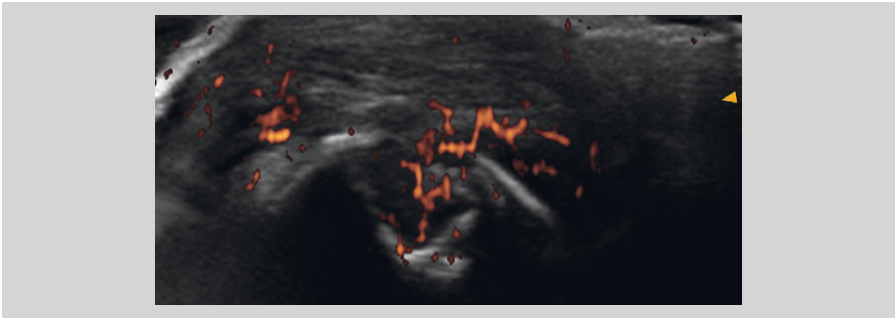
Ultrasound-detected erosion of a metacarpal head in a dorsal longitudinal with associated inflammatory synovitis (both grayscale and power Doppler).
